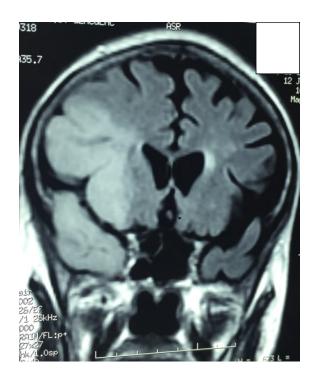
MRI of focal area at admission.
